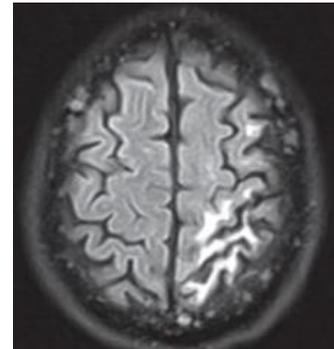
MRI examination results.
